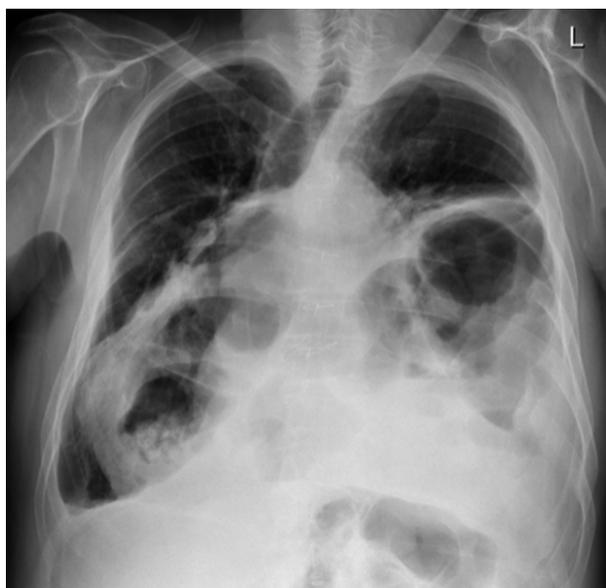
Chest X-ray: bowel is visualized in the thorax
